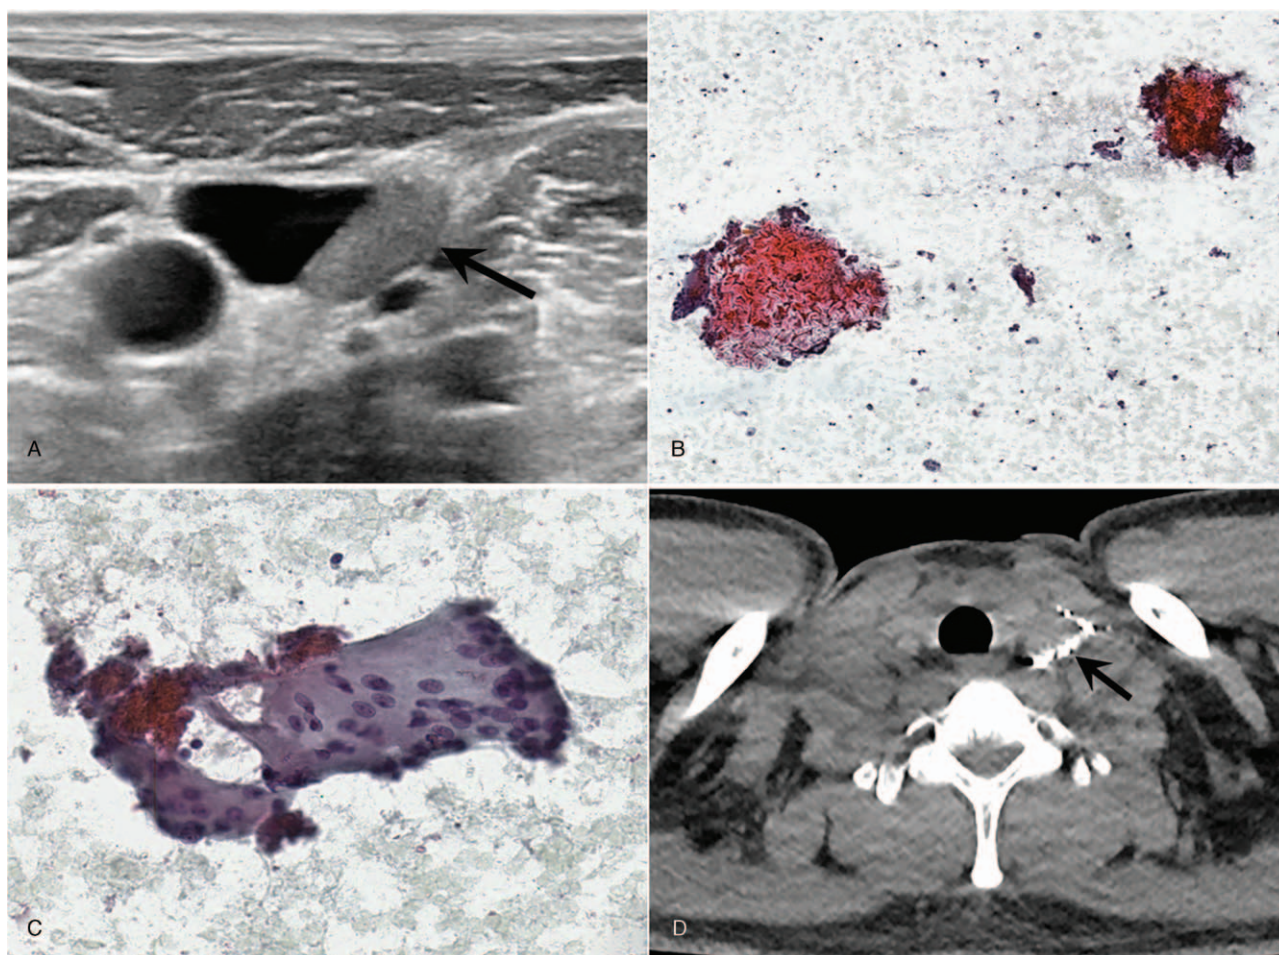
(A) Neck ultrasonography for the surveillance of thyroid cancer. There is a suspicious lymph node in the left level IV. The lymph node shows homogeneous hyperechogenicity with loss of fatty hilum. (B) Cytology of the left level IV lymph node ($\times 100$). There are several clusters of eosinophilic, glistening foreign substances mixed with some giant cells. (C) Cytology of the left level IV lymph node ($\times 400$). At a higher magnification, multinucleated giant cells are engulfing the eosinophilic granular materials. (D) Chest computed tomography obtained after the procedure. There are multiple strongly hyperattenuating foci with beam hardening artifacts by the embolic materials (arrow) in the left lower neck.
